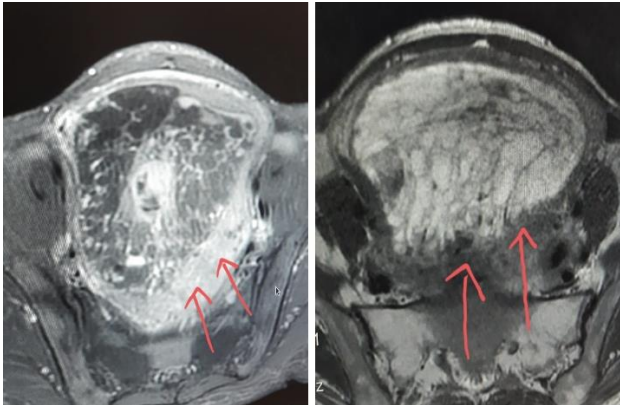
T1 and T2 weighted MRI images showing myometrial invasion (axial view).
